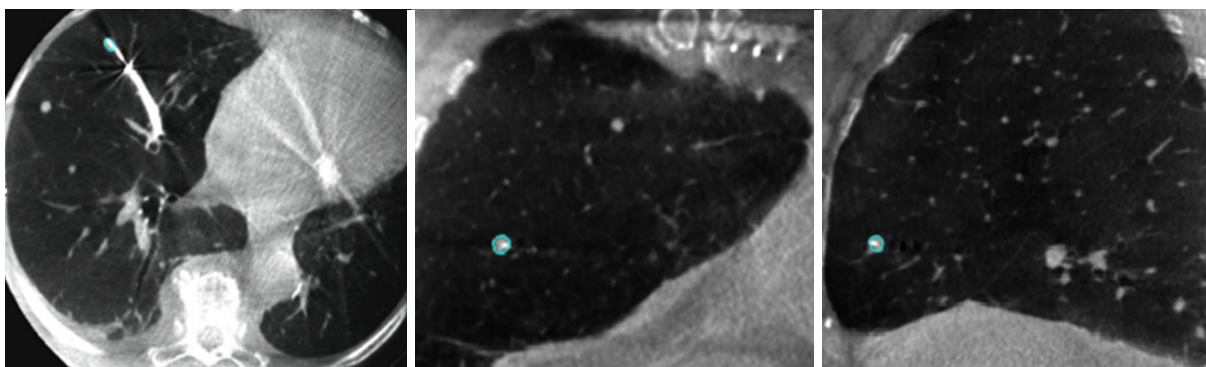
Cone-beam computed tomography images in axial, coronal and sagittal views of a 5 mm × 3 mm nodule with needle in lesion confirmation.
